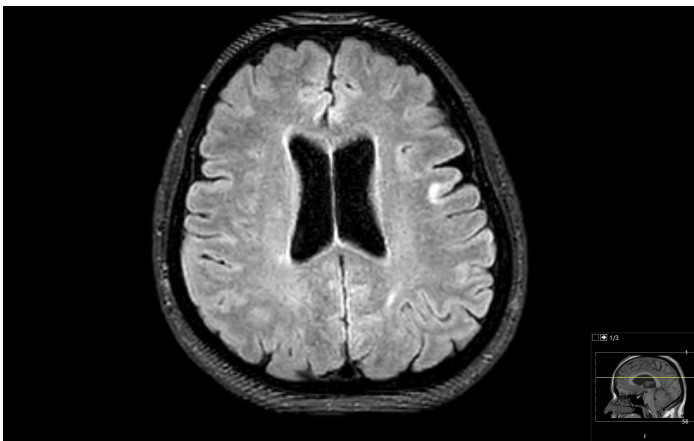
Axial FLAIR and T2 weighted images of a RA patient with cortical involvement.
